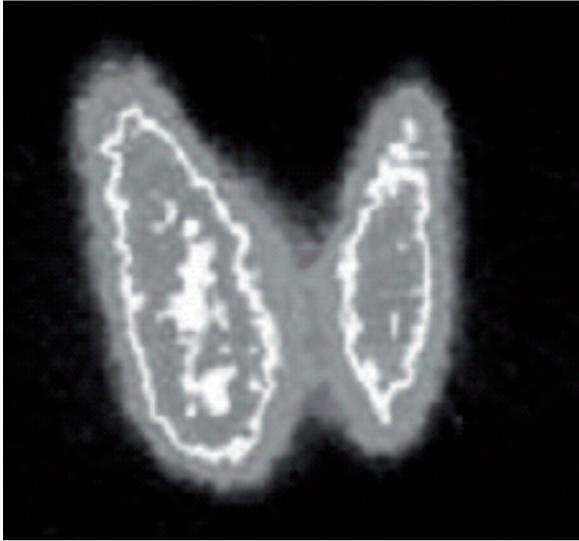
Thyroid scintigraphy performed with $^{99m}\text{TcO}_4^-$ in a patient with Graves' disease. The scintigraphic picture shows a thyroid of modestly increased size, mainly in the right lobe with high and homogeneous uptake of the tracer. It is possible to note the almost absent background activity.
